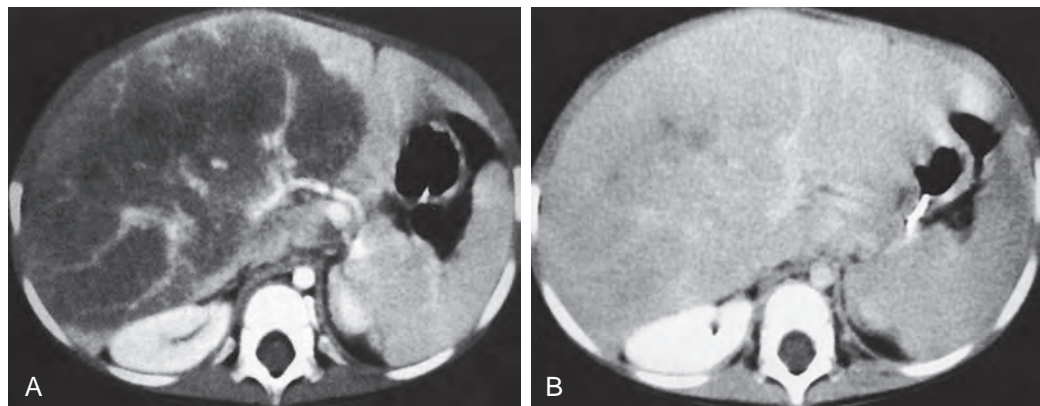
Hepatosarcoma. Dynamic, contrast-enhanced CT image reveals a large, low-density liver mass arising in the right lobe and extending into the medial segment of the left lobe. A. Arterial phase. B. Delayed scan.
